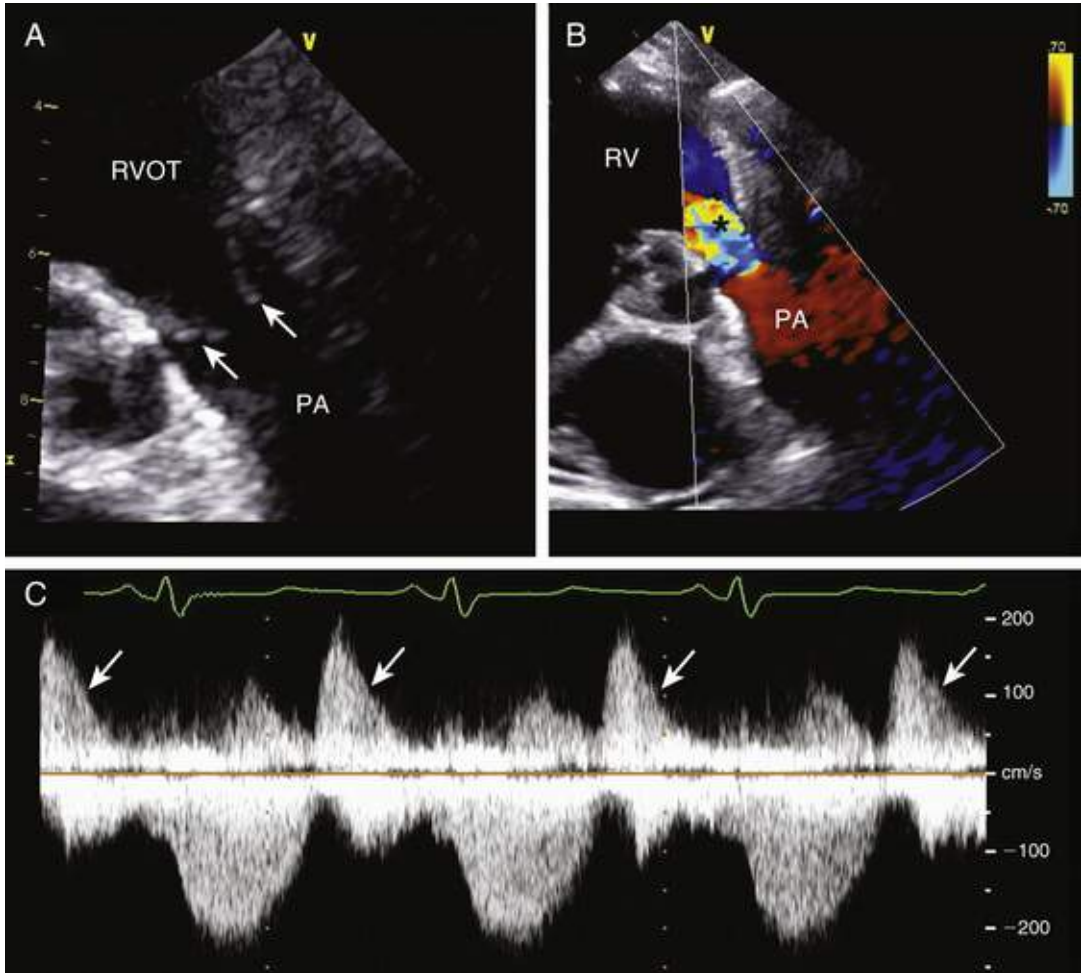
Transthoracic echocardiography images of the pulmonic valve in a patient with carcinoid heart disease. A, Zoomed two-dimensional parasternal short-axis image at the level of the aortic valve shows the pulmonic valve in long axis in mid-diastole, demonstrating a marked thickening with retraction of the pulmonic valve leaflets (*arrow*) and resulting in failure of leaflet closure. B, Color Doppler imaging of the pulmonic valve in the same view shows a broad regurgitant jet occupying the entire width of the right ventricular outflow tract (*RVOT*), consistent with severe pulmonic valve regurgitation (*). *RV*, Right ventricle; *PA*, pulmonary artery. C, Continuous-wave Doppler imaging across the pulmonic valve demonstrates a dense, diastolic, pulmonary regurgitant jet that returns to baseline before the end of diastole, consistent with severe PR (*arrow*). (From Luis SA, Pellikka PA. Carcinoid heart disease: diagnosis and management. *Best Pract Res Clin Endocrinol Metab* 2016;30:149.)
